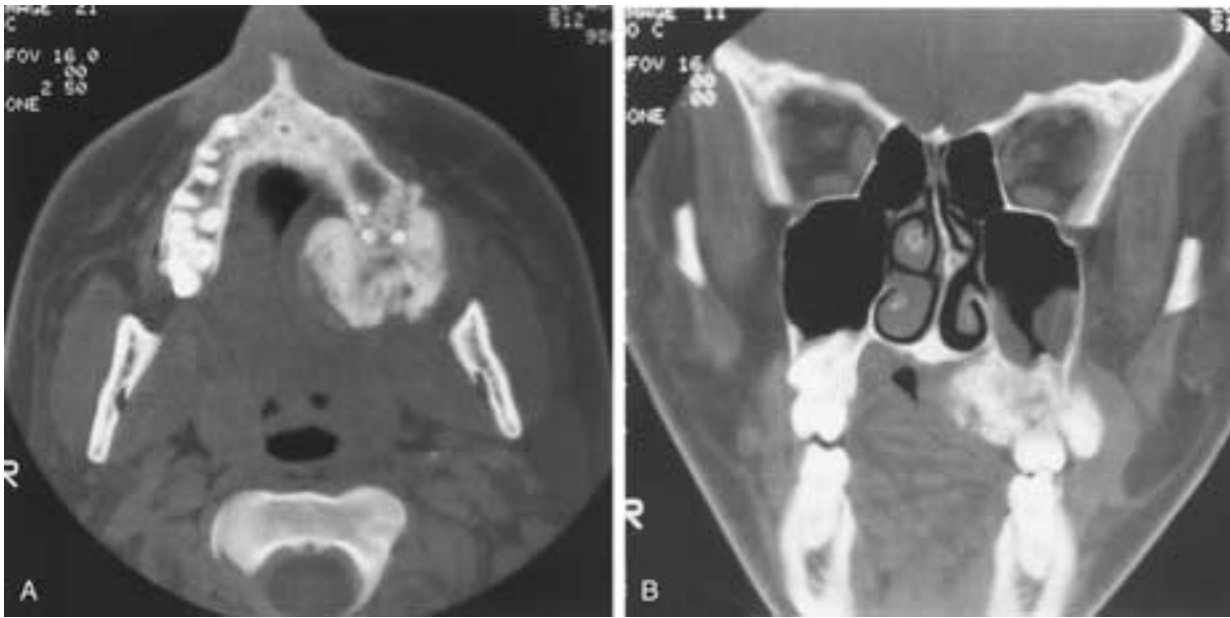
Chondroblastic osteosarcoma of the left maxilla. A, Axial CT through the maxilla demonstrates a sclerotic, destructive lesion in the left maxilla, with extension into the lower portion of the left antrum. B, Coronal CT demonstrates the sclerotic, destructive, expansile lesion in the left maxilla and in the lower left maxillary antrum.
